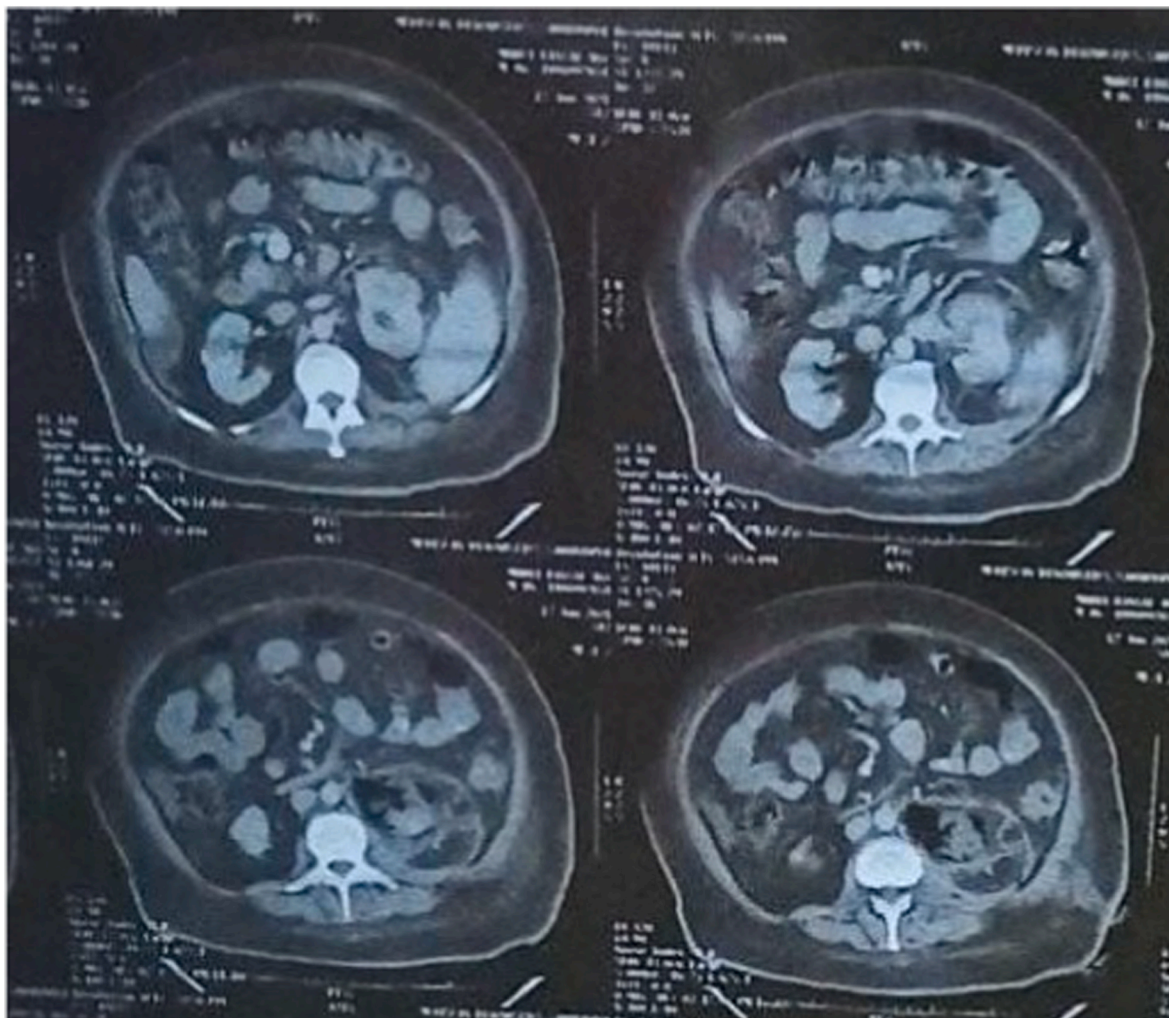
Computed tomography images showing left emphysematous pyelonephritis.
